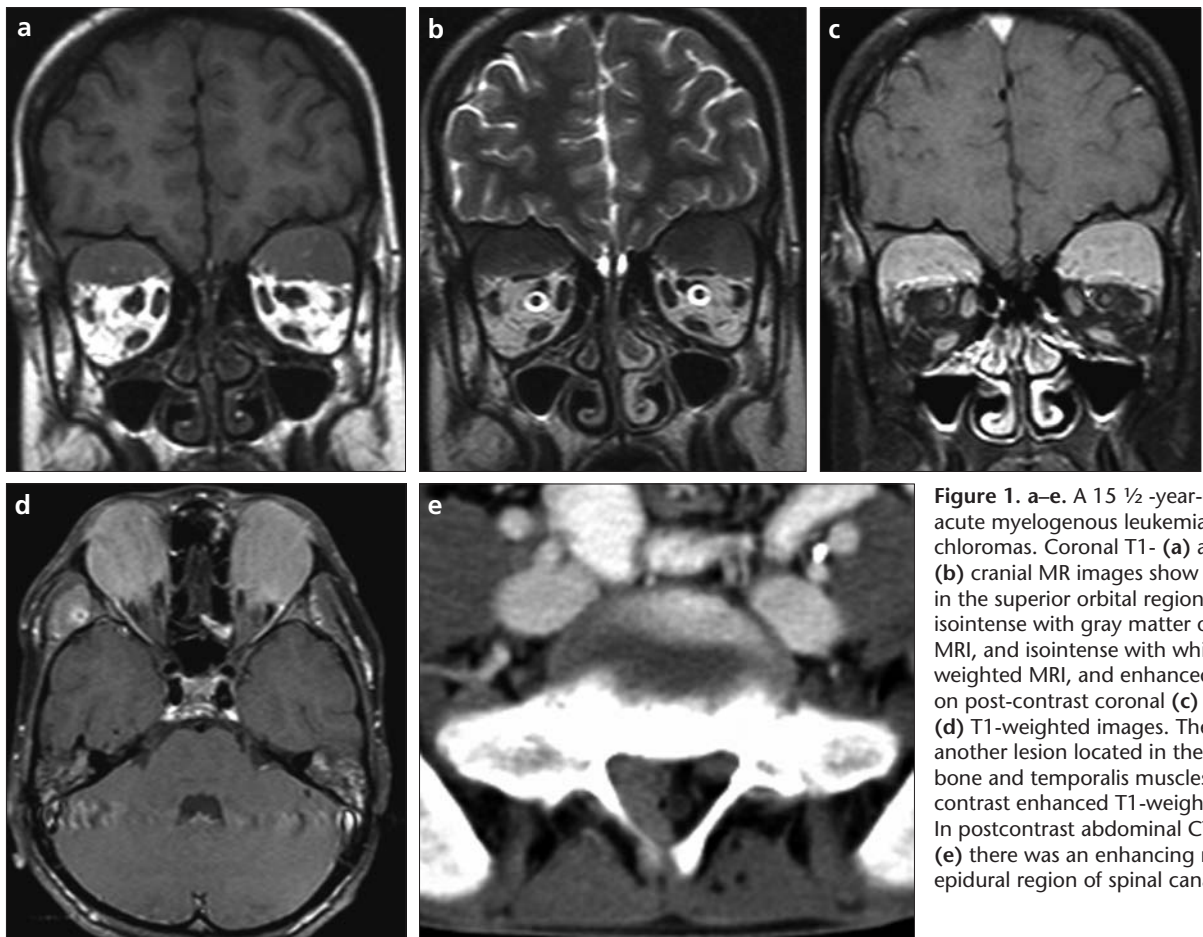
a–e. A 15 ½-year-old boy with acute myelogenous leukemia and multiple chloromas. Coronal T1- (a) and T2-weighted (b) cranial MR images show bilateral masses in the superior orbital region which are isointense with gray matter on T1-weighted MRI, and isointense with white matter on T2-weighted MRI, and enhanced homogenously on post-contrast coronal (c) and axial (d) T1-weighted images. There was also another lesion located in the right temporal bone and temporalis muscles, seen on axial contrast enhanced T1-weighted image (d). In postcontrast abdominal CT examination (e) there was an enhancing mass in the right epidural region of spinal canal.
